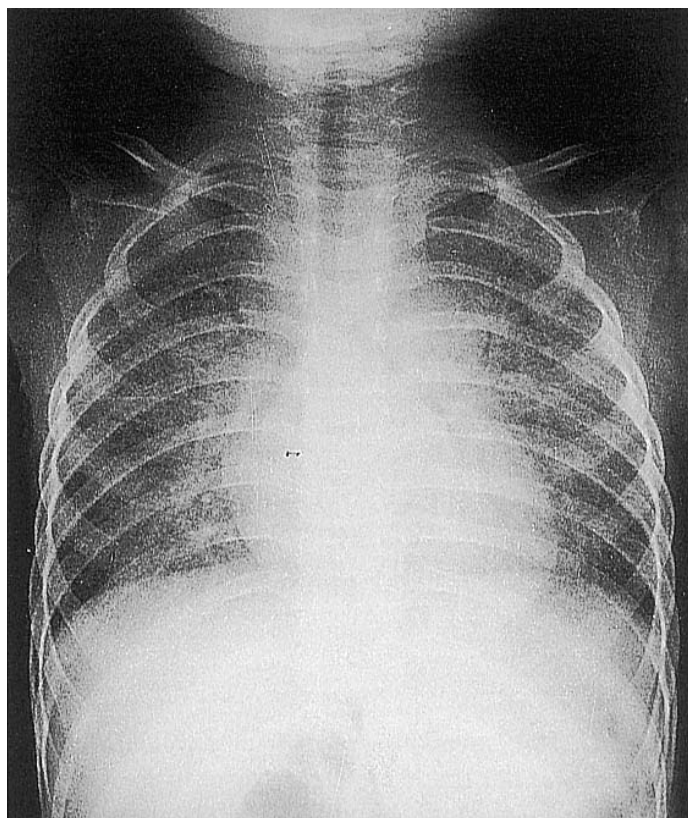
Chest x-ray at admission revealed bilateral reticulonodular shadowing.
